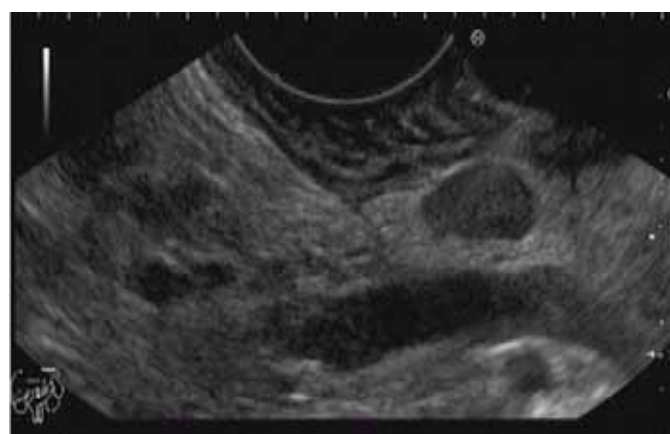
Thickening of the duodenal wall, a pancreatic head compatible with pancreatitis and peripancreatic adenopathies were observed on endoscopic ultrasound examination.
